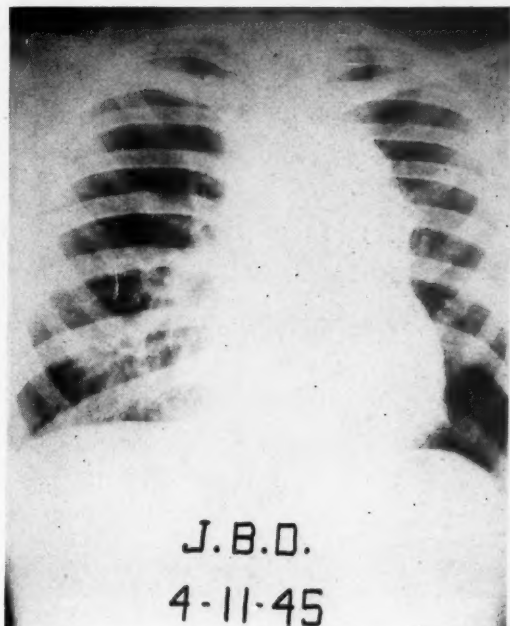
Unilateral mass protruding from left superior mediastinum. Biopsy of supraclavicular lymph node revealed Hodgkin's disease. Temporary improvement with deep x-ray therapy.
